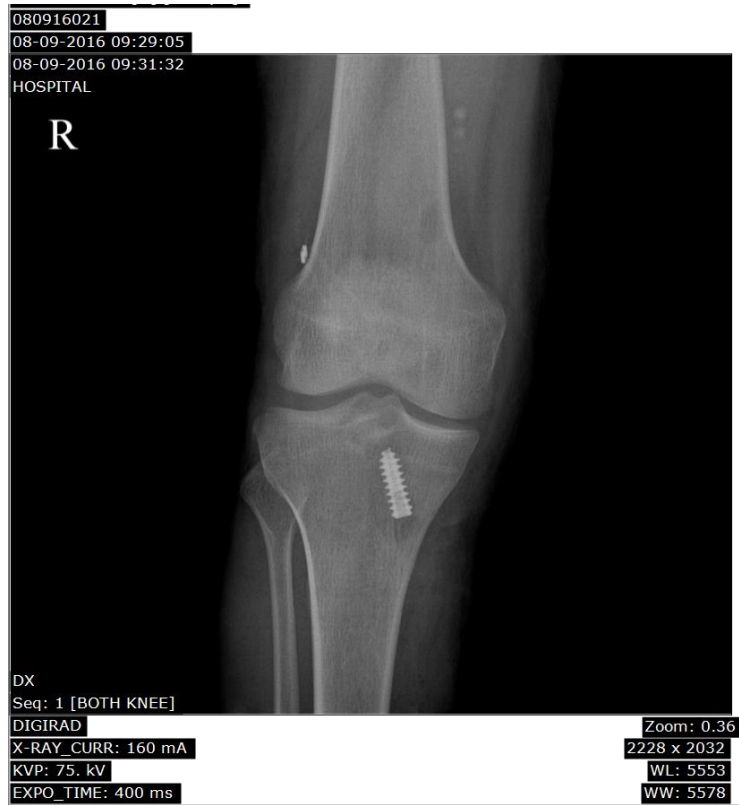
Post operative antero posterior radiographs of the knees during 4 month follow up showing proper positioning of endobutton and interference screw without loosening or pullout.
